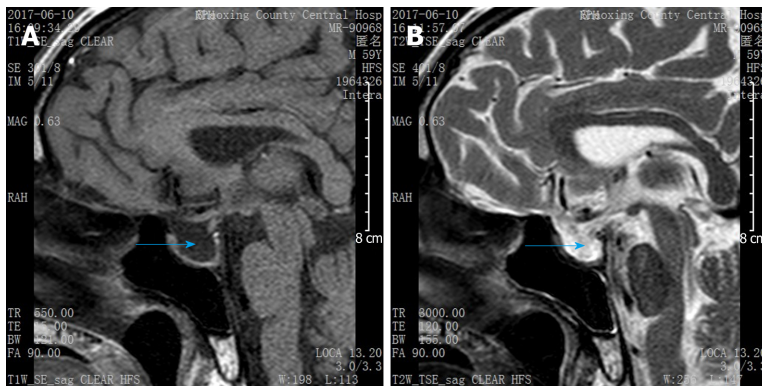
Sagittal view of T1 and T2 weighted magnetic resonance images. A: Sagittal view of T1 weighted magnetic resonance (MR) image; B: Sagittal view of T2 weighted MR image. Arrow showing empty sella turcica filled with cerebrospinal fluid.
